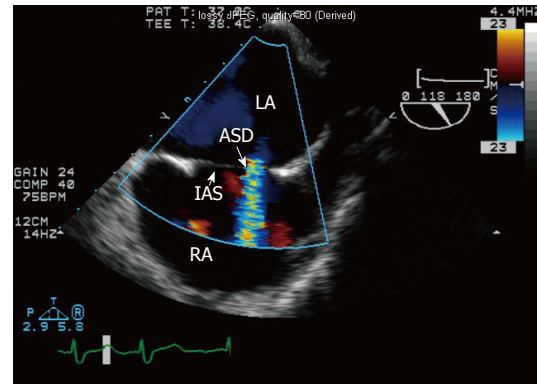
Color flow Doppler demonstrating a small atrial septal defect with left-to-right shunt. ASD: Atrial septal defect; IAS: Interatrial septum; LA: Left atrium; RA: Right atrium.
